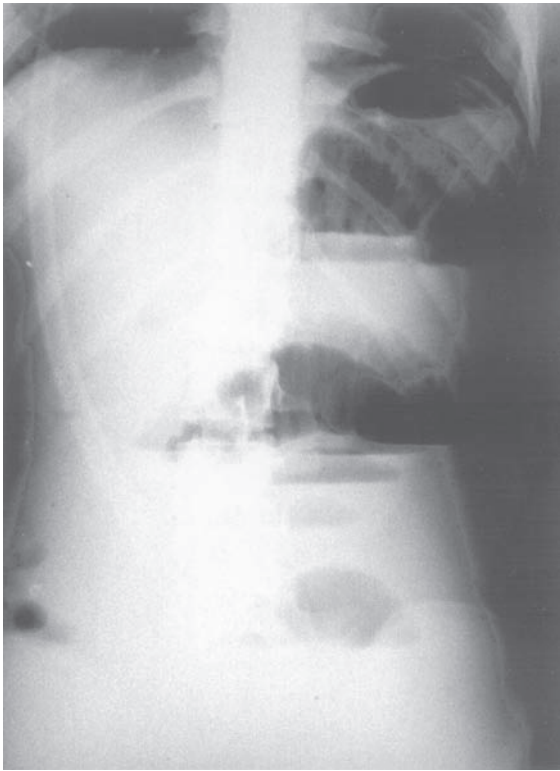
Abdominal radiography shows multiple air-fluid levels in small bowel obstruction.
